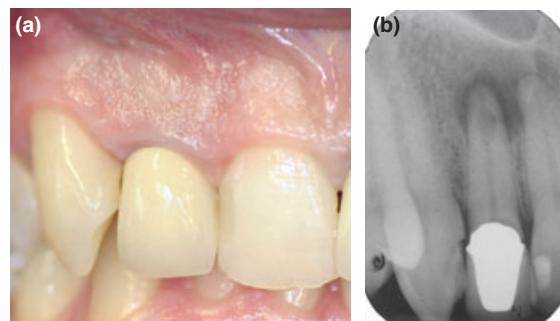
(a) Clinical view showing preoperative status of crowned tooth 12. (b) Preoperative radiograph of tooth 12 demonstrating periradicular radiolucency and internal root resorption.
